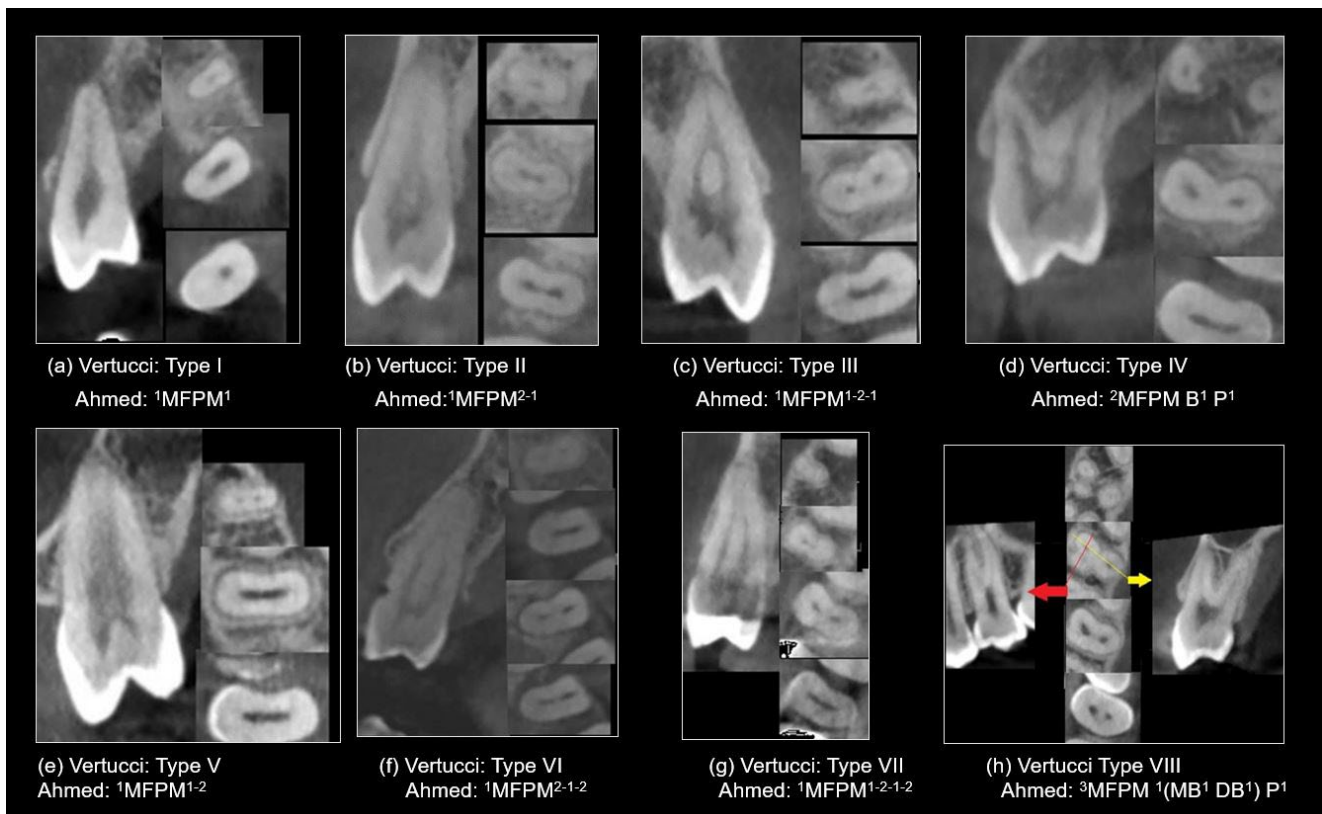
Representative cone-beam computed tomography images in sagittal and axial views (apical, middle, coronal), showcasing various root canal system configurations in maxillary first premolars (MFPM) based on Vertucci's and Ahmed's classifications.
